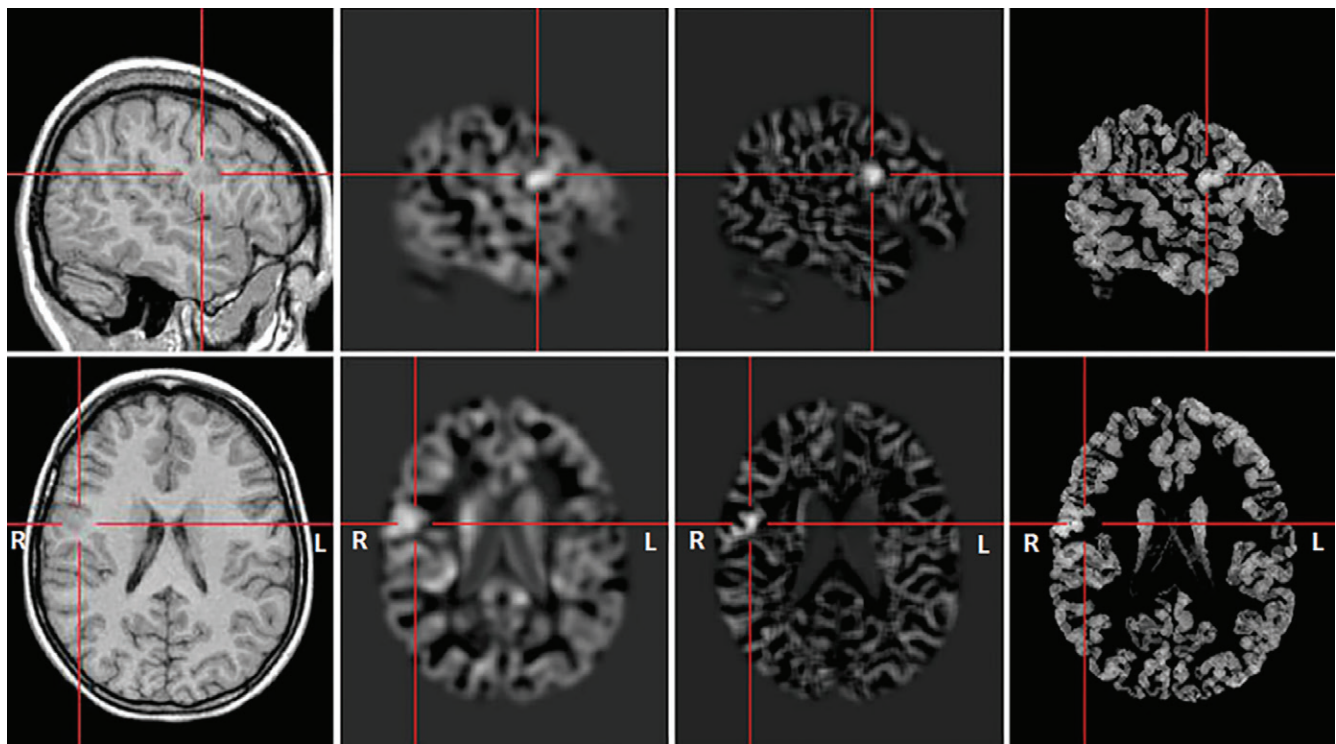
From left to right, T1-weighted MRI scans with calculated extension, junction, and thickness morphometric maps in focal cortical dysplasia IIb (age and sex unknown). The morphometric maps show the signs of a dysplastic lesion (ie, abnormal gyration, blurring of the gray-white matter junction, and abnormal cortical thickness). The red lines are crosshairs, and the center point of the red lines indicate the location of the presumed epileptogenic zone. (Reprinted, with permission, from reference 16.)
